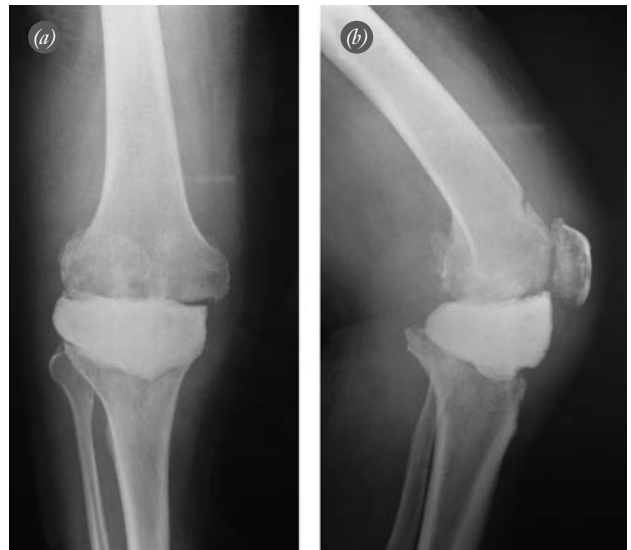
(a, b) X-ray taken after the removal of prosthetic components and placement of cement spacer in the joint space.
